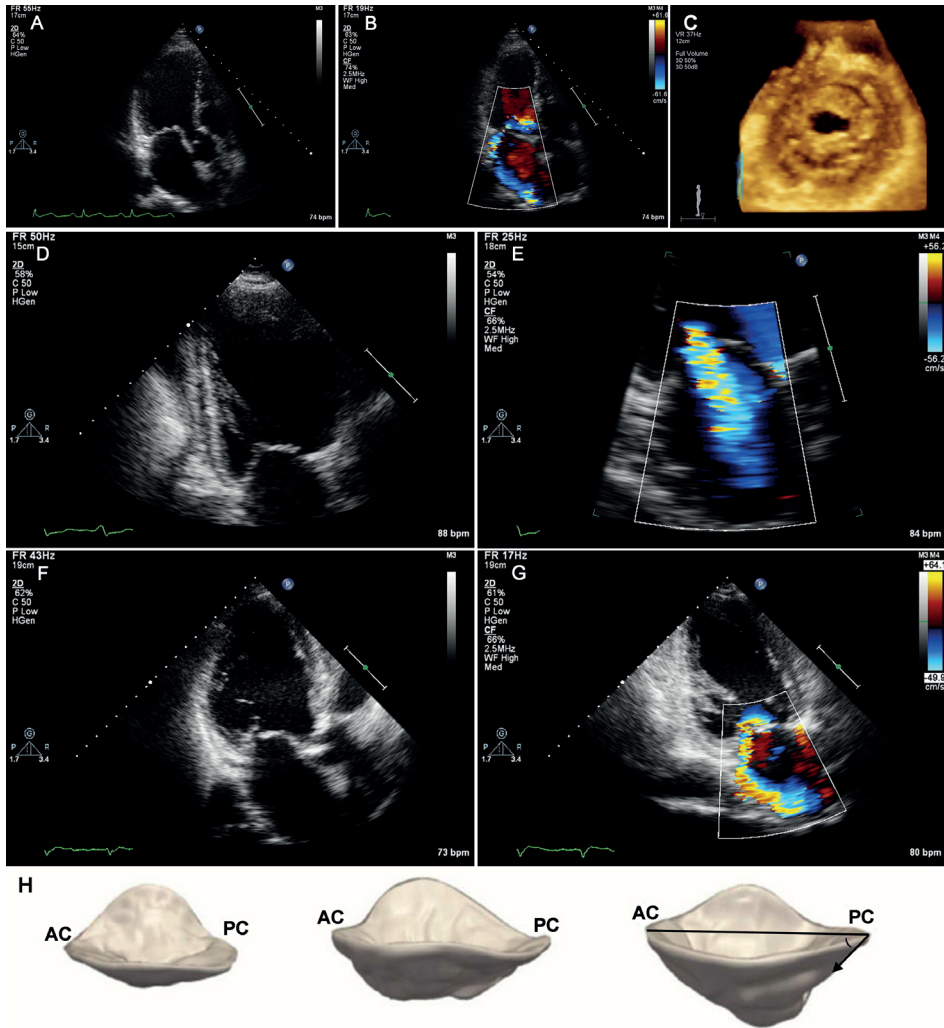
Mitral valve restriction seen with 2D trans-thoracic gray scale and color imaging in rheumatic disease with systolic and diastolic restriction (A and B, C showing the 3D surgical view with reduced valve opening), in dilated cardiomyopathy with symmetric systolic restriction (D and E) and ischemic cardiomyopathy (F and G) with asymmetric systolic restriction. In the bottom panel (H), 3D echocardiographic virtual models are seen from the commissure-to-commissure view. The 3D tenting area and tethering angle of segment P3 (arrow-line) may predict recurrent mitral regurgitation after annuloplasty. AC denotes anterior commissure and PC denotes posterior commissure. Reproduced with permission from Bouma et al.³⁷
